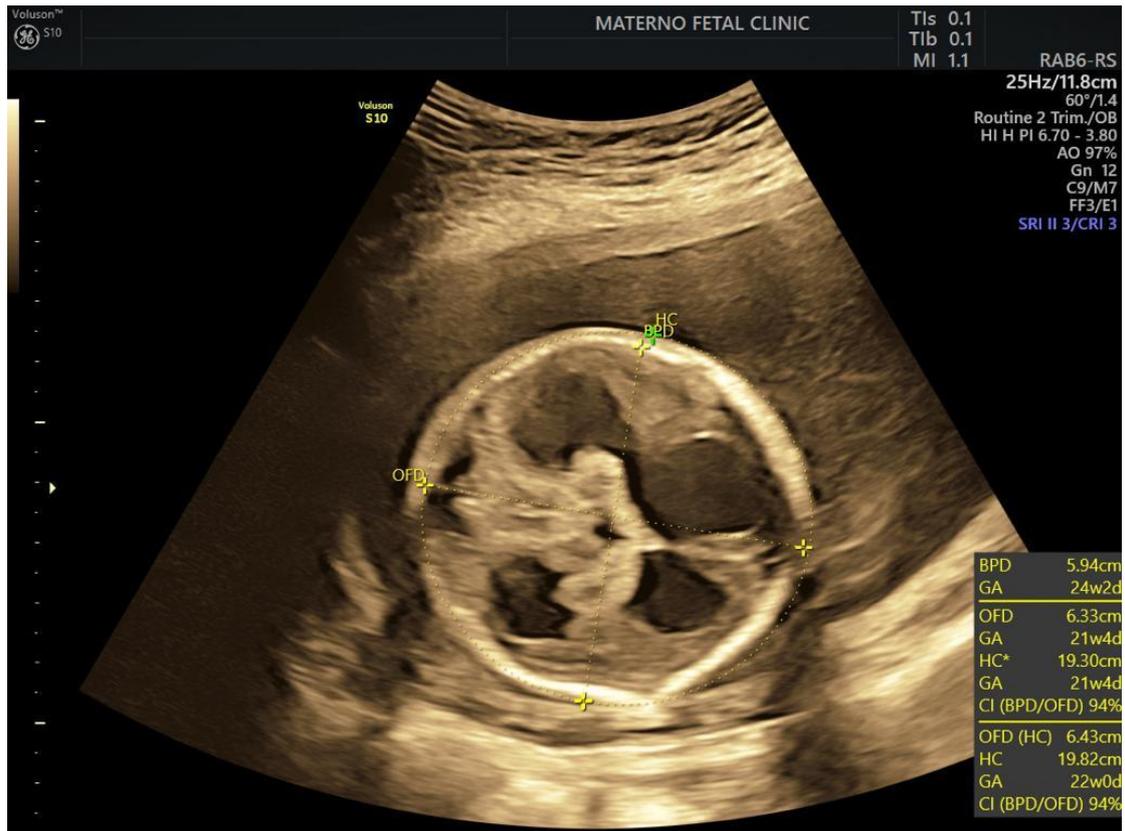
Two-dimensional ultrasound showing ventriculomegaly of the studied patients
